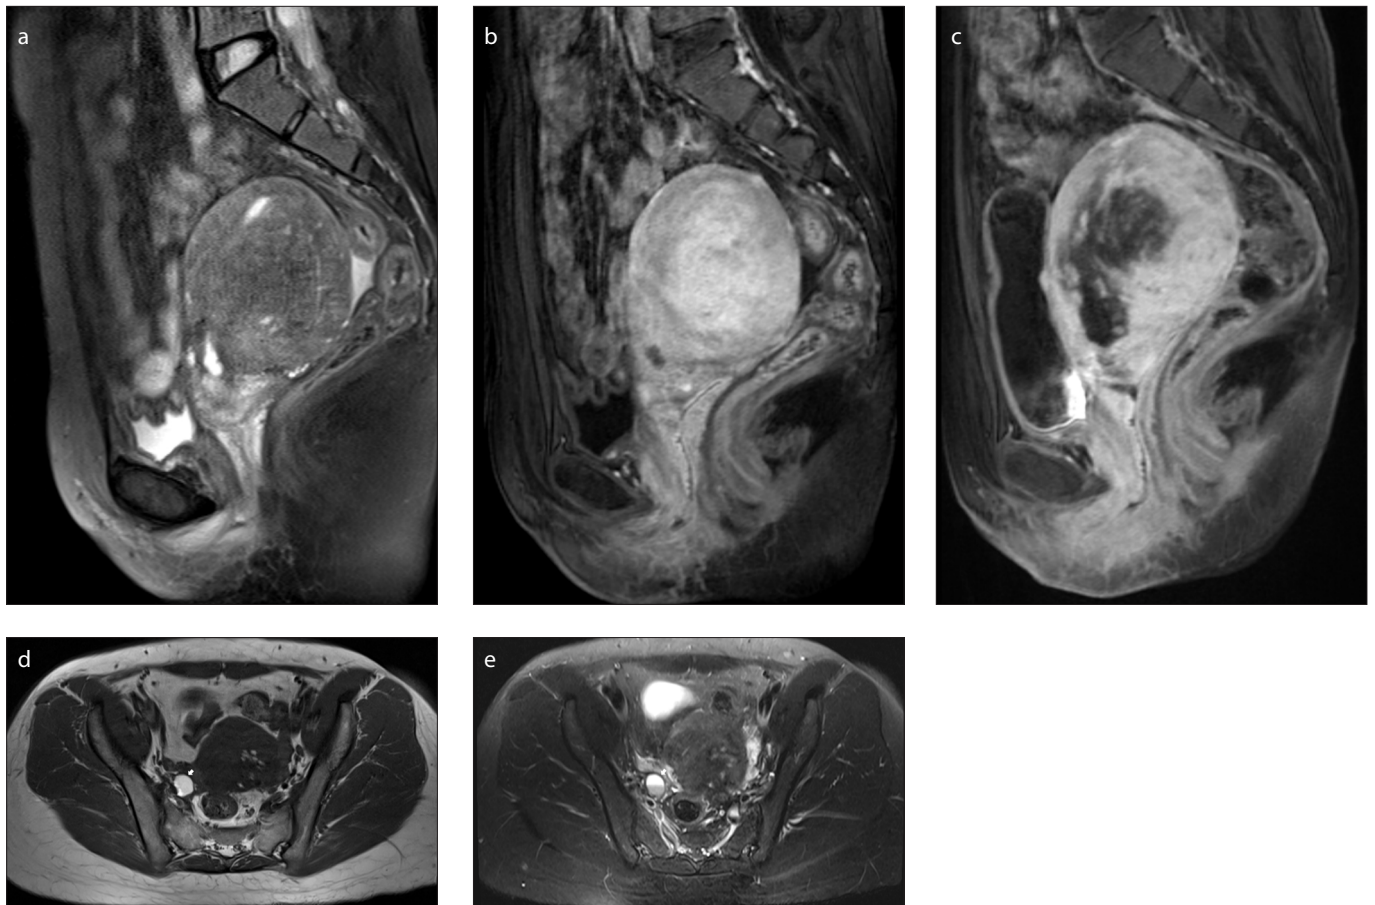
a–e. MRI of a 41-year-old woman with focal adenomyosis and accompanying endometriosis. Her serum CA125 level was 545.8 U/mL. Preprocedural sagittal T2-weighted image (a) shows a focal thickening of the junctional zone which presents a relative low signal intensity area in the myometrium. Preprocedural sagittal contrast-enhanced T1-weighted image (b) shows homogeneous enhancement of lesion. Follow-up sagittal contrast-enhanced T1-weighted image (c) 12 days after UAE shows an irregularly shaped partial necrosis with ill-defined boundary that cannot totally cover the adenomyosis, which represents incomplete necrosis. Preprocedural axial T1-weighted image with relative hyperintensity (d, white arrow) and T2-weighted image with the intermediate to low signal intensity (e, white arrow) respectively show a visible endometrioma of the right ovary.
